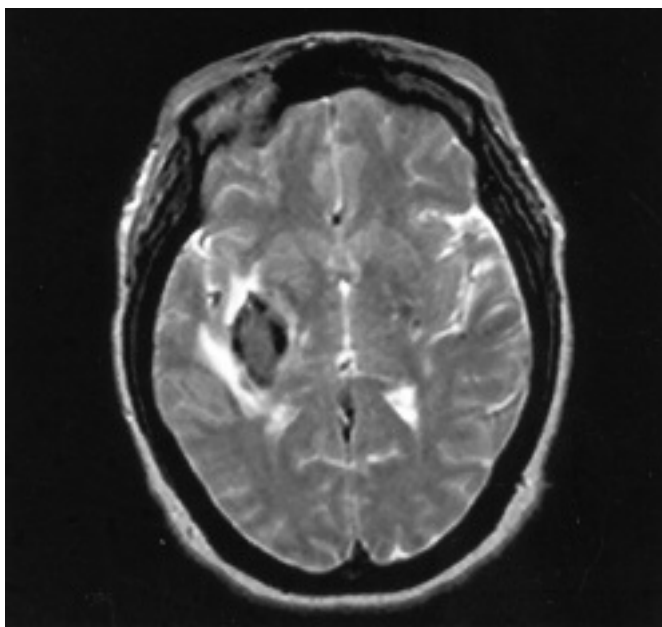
Subacute T2-weighted axial MR image of a spontaneous right putamenal hemorrhage showing peri-hematomal edema.
